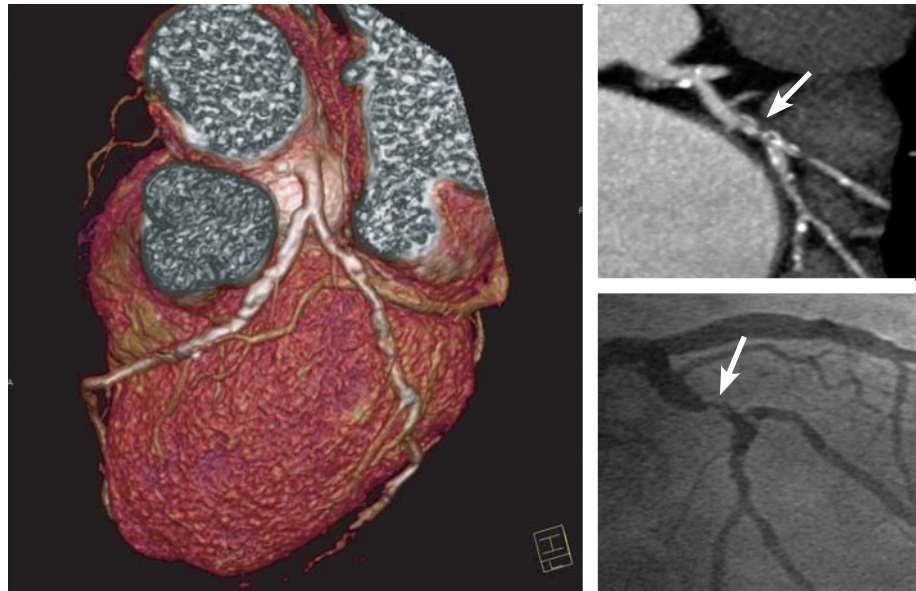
Severe atherosclerotic lesions in the LAD and CX in a patient who had a heart rate between 89 and 93 bpm during the 64-slice CT examination. Owing to the increased temporal resolution of 64-slice CT, the coronary vessels can be evaluated free of motion artifacts. MIP reconstruction of the CX coronary artery revealed significant stenosis in conjunction with complex calcified and non-calcified plaque structures (*arrow*). The CX stenosis was confirmed by CAG
